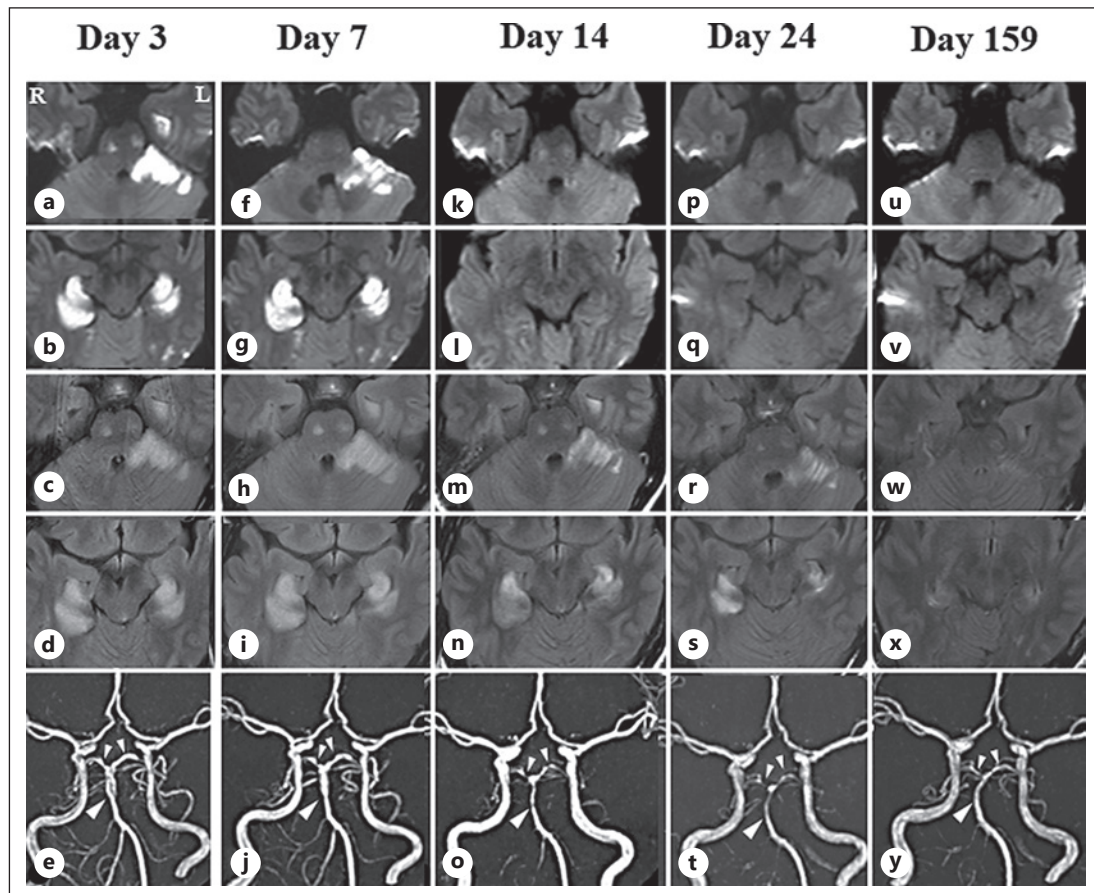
Serial MRI and MRA findings in case 1. Brain MRI on day 3 after onset showing high signal intensity in bilateral hippocampus, left thalamus, splenium of corpus callosum, bilateral occipital lobe, pons, and left cerebellum on DWI (a, b) and FLAIR (c, d). MRA showing no significant vasoconstriction (e, arrowheads). Brain MRI on day 7 after onset showing slight enlargement of high signal intensity on DWI (f, g) and FLAIR (h, i). MRA showing segmental vasoconstriction in the bilateral posterior cerebral arteries and basilar artery (j, arrowheads). Brain MRI on day 14 after onset showing a reduction of high signal intensity on DWI (k, l) and FLAIR (m, n). MRA showing segmental vasoconstriction in the bilateral posterior cerebral arteries and basilar artery (o, arrowheads). Brain MRI on day 24 after onset showing a well reduction of high signal intensity on DWI (p, q) and FLAIR (r, s). MRA showing slight segmental vasoconstriction in the bilateral posterior cerebral arteries and basilar artery (t, arrowheads). Brain MRI on day 159 after onset was normal (u–x). MRA showing complete resolution of the vasoconstriction (y, arrowheads).
